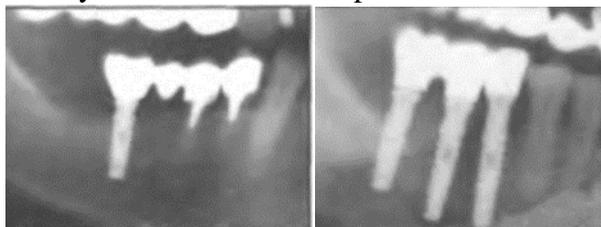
X-ray of the patient T. 46 L. in the area of implants loaded with bridges after selective resurfacing.
